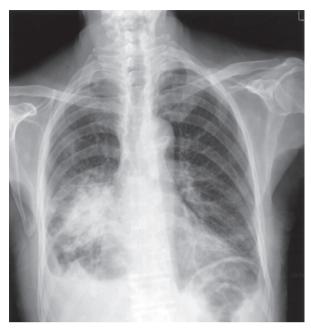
Chest radiograph showing right lower lung field consolidation with air-bronchogram and pleural effusion.
